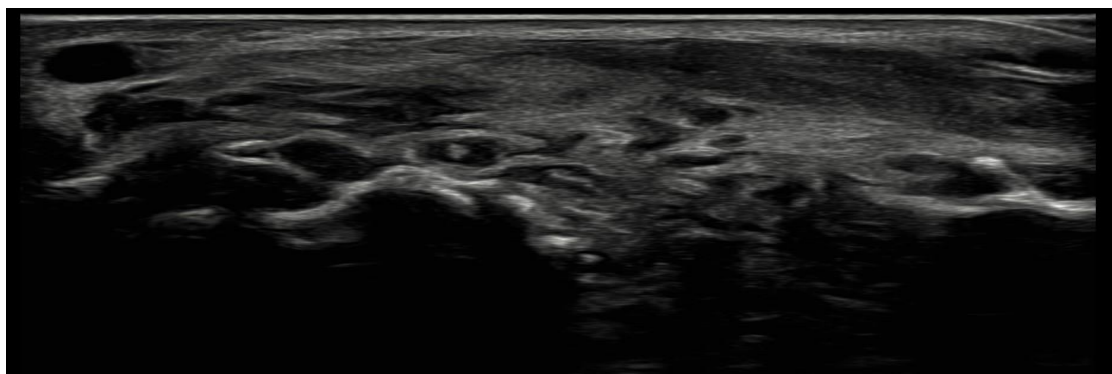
Ultrasound image of the hand demonstrating the characteristic “dot-in-circle” sign of mycetoma, seen as hyperechoic foci within hypoechoic inflammatory lesions.
